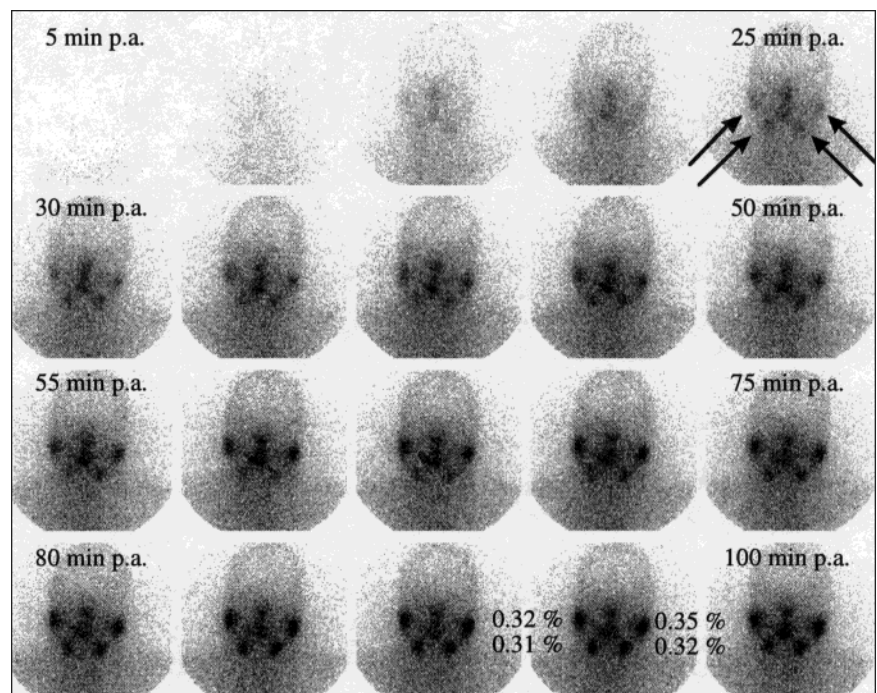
Sequential quantitative salivary gland scintigraphy started directly after the oral application of 400 MBq ¹³¹I. Note the beginning accumulation of radioiodine in the salivary glands from as early as 25 min after oral application with increasing uptake over time.
